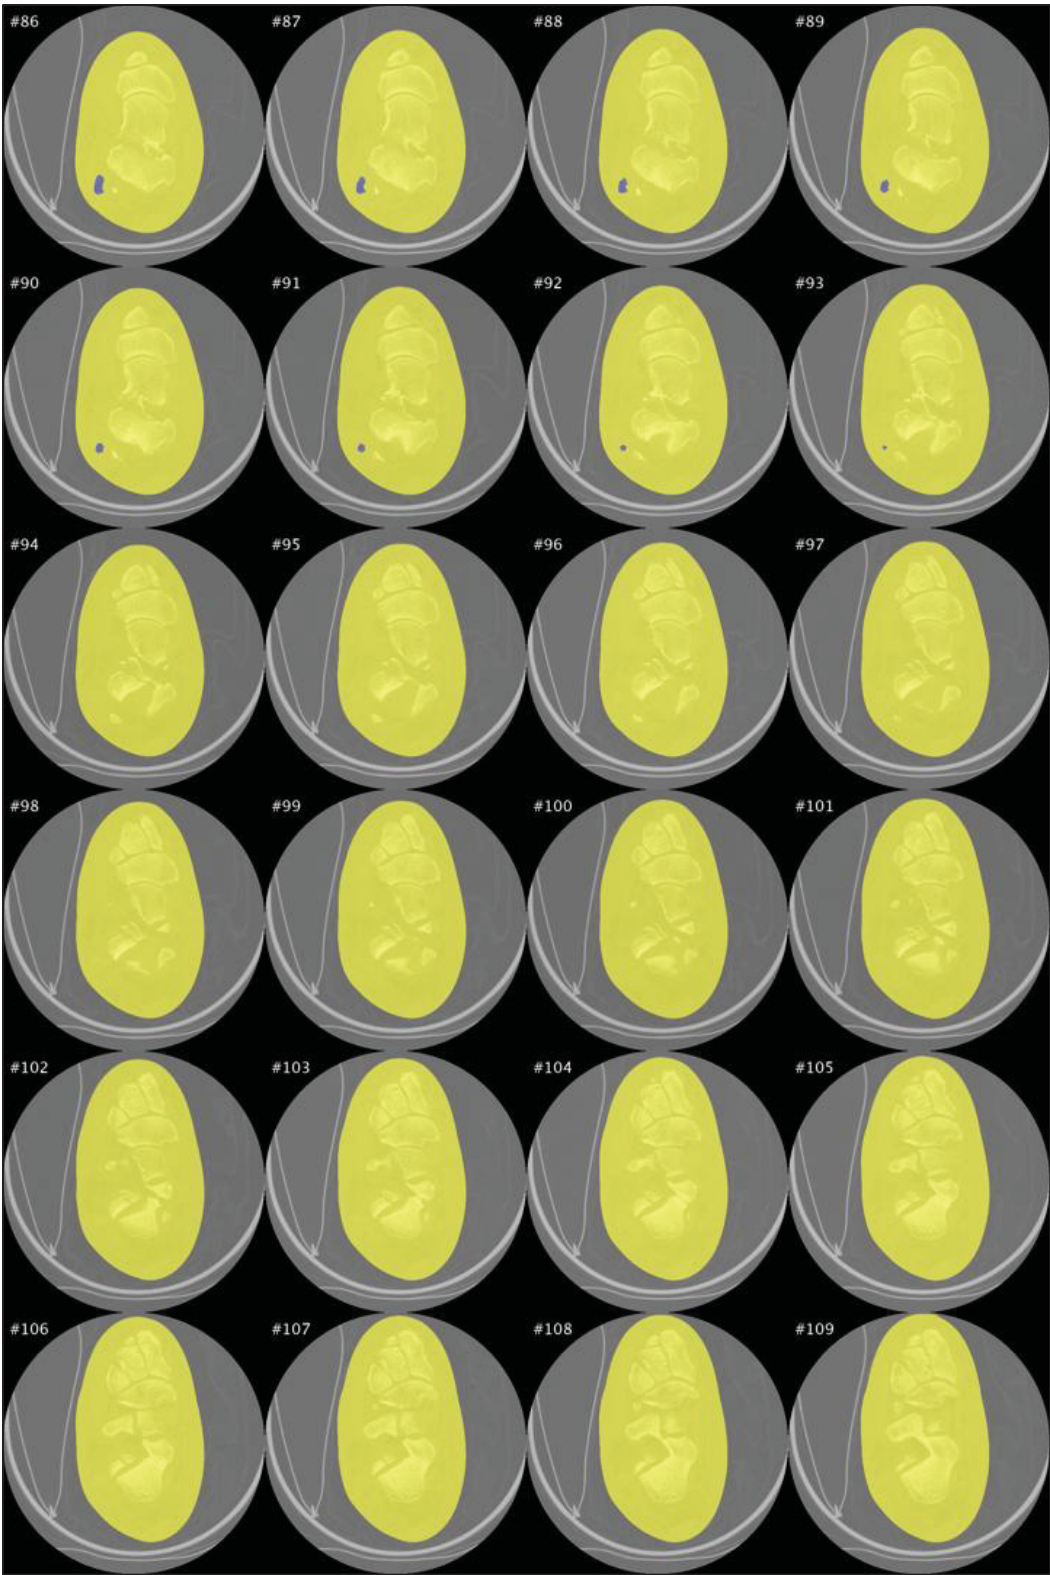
Figure-A I-3: Slice-by-slice segmentation for a CT-Scan sample, slice 86 to 109
